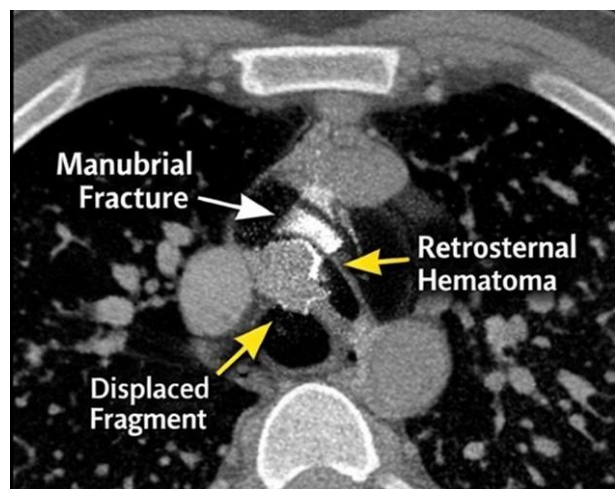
Axial CT image showing a fracture of the manubrium sterni, with adjacent soft tissue swelling and a small retrosternal hematoma.
